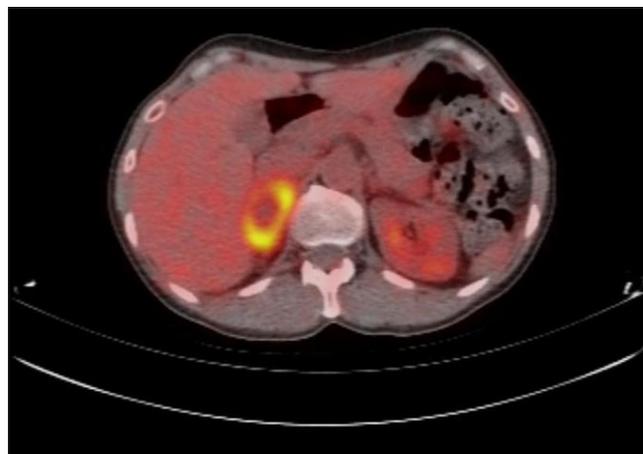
PET/CT showing pathological FDG uptake in the right adrenal gland with central necrosis
